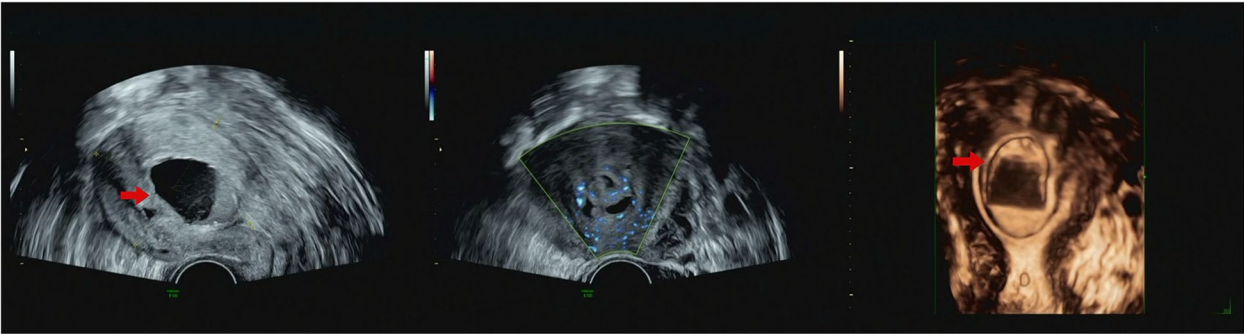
The three-dimensional color ultrasound examination in case1 reveals that the uterine nodule exhibited characteristics of inhomogeneous echogenicity, with hypo or anechoic properties, and the presence of streaks indicating blood flow signal surrounding the mass
